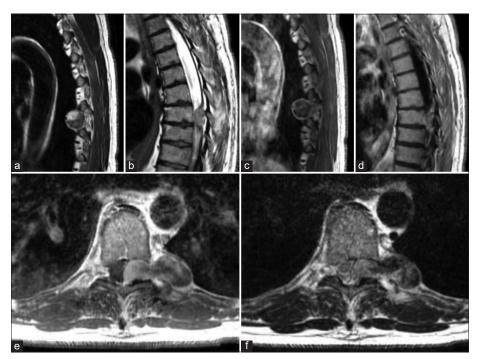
(a and b) Sagittal T_2 -weighted MRI scans taken at the time of presentation show a slightly hyperintense heterogeneous mass at the level of T8-T9. (c and d) T1-weighted MRI scans taken after gadolinium administration show a hypointense mass with circumferential enhancement. Axial T_1 (e) and T_2 (f) images show an extramedullary intradural dumbbell-shaped mass.
